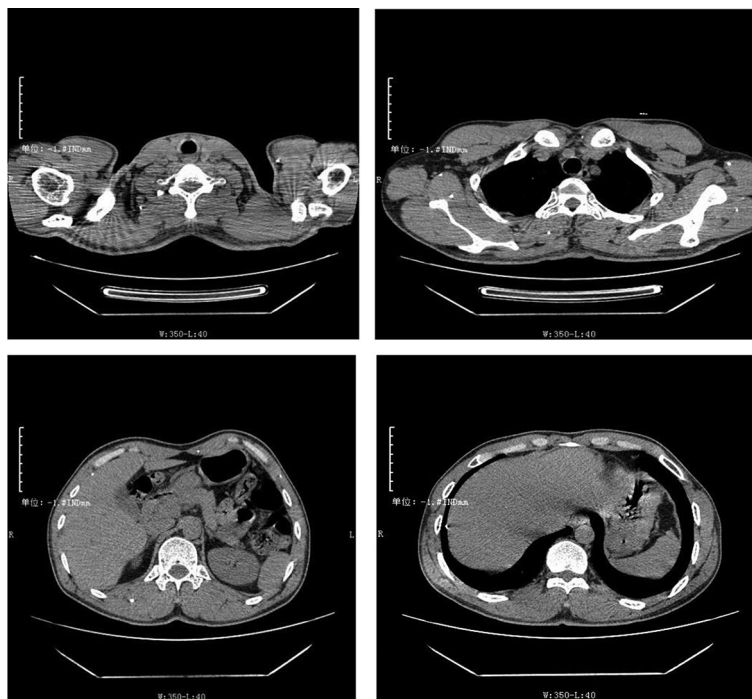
CT of the neck and chest and abdomen. Neck, chest, and abdominal CT scans reveal multiple high-density calcifications within the soft tissues of the neck, chest, back, abdominal wall, and along the liver margin
